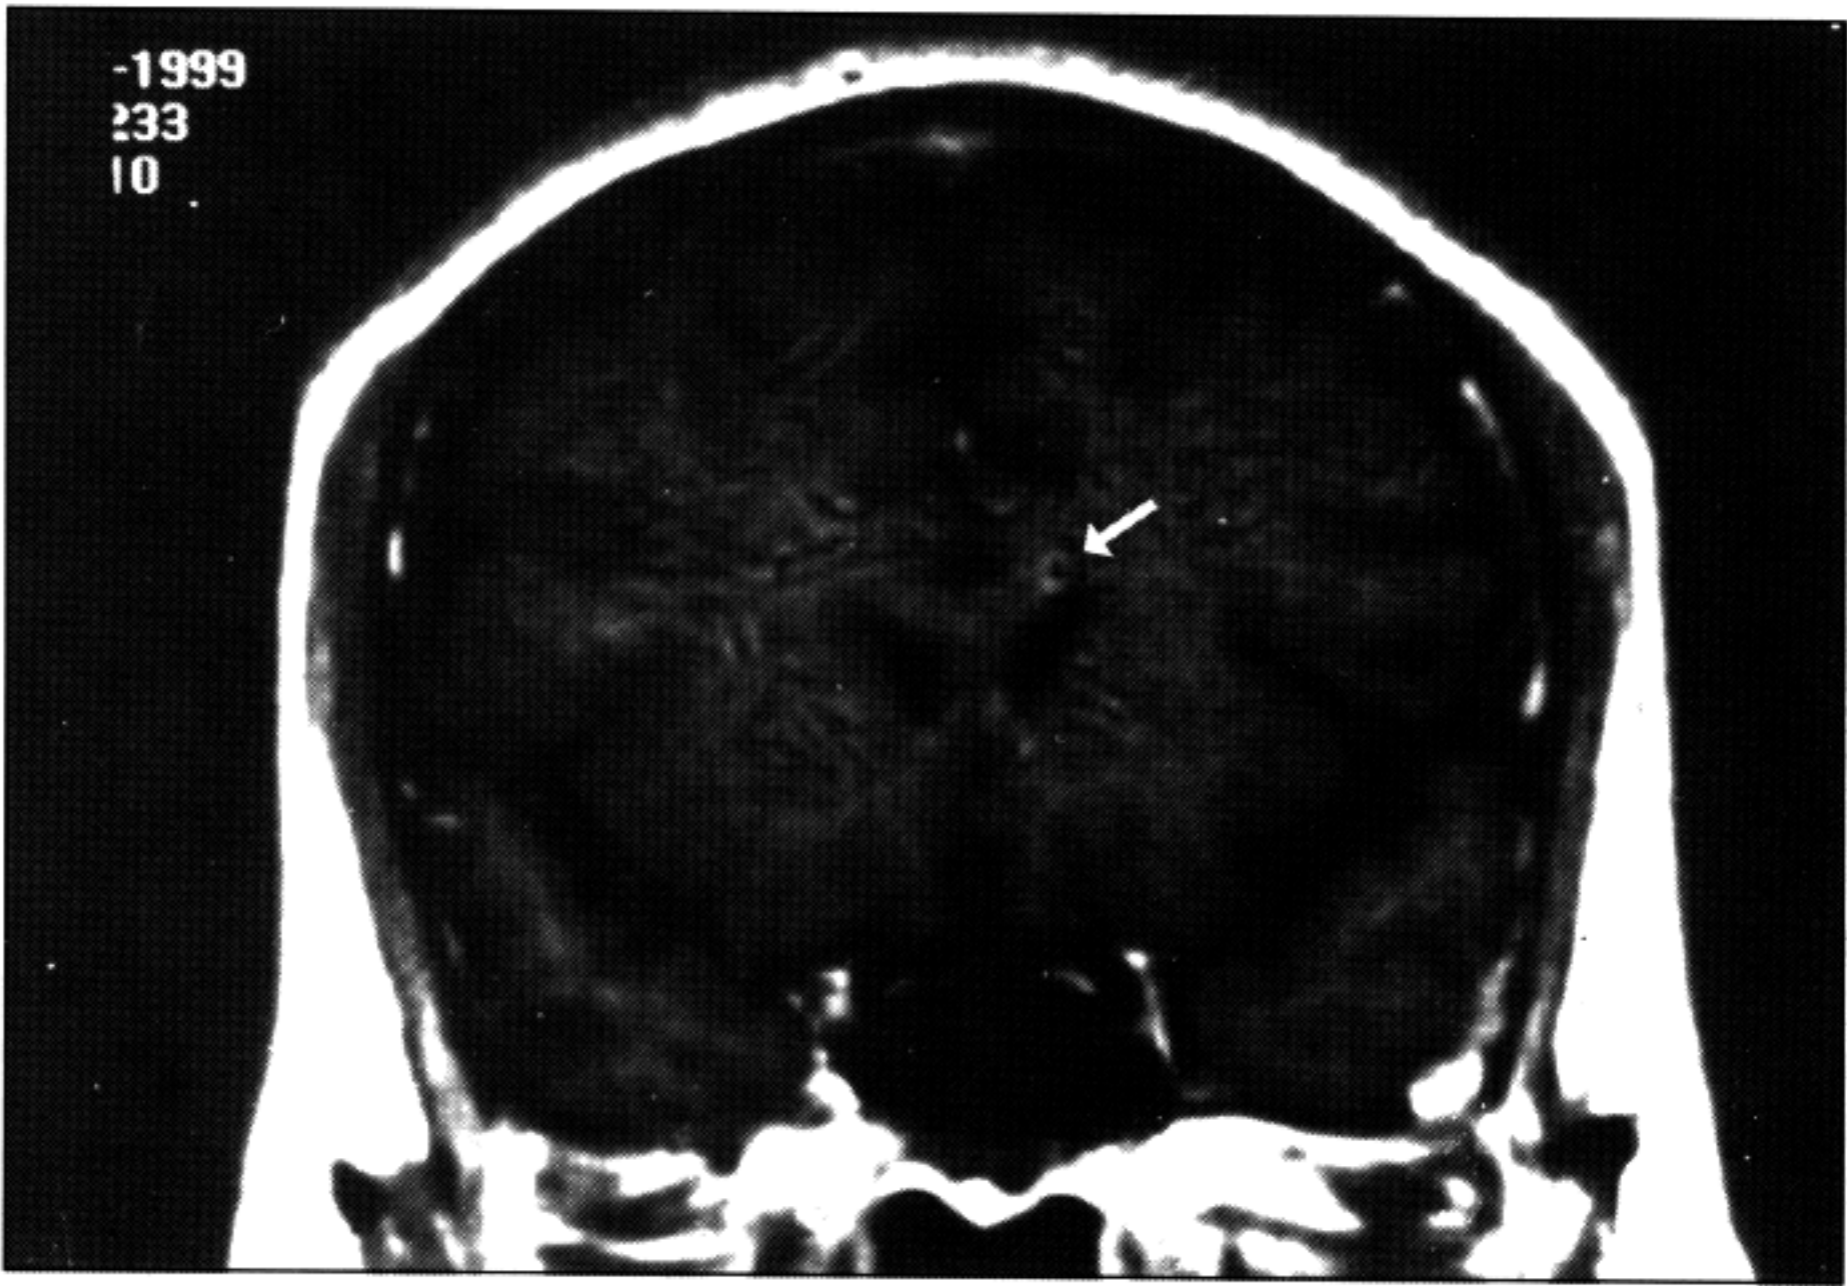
Coronal T1W1 post gadolinium MRI showing a focal 3 mm ring enhancing lesion in the corpus callosum.
